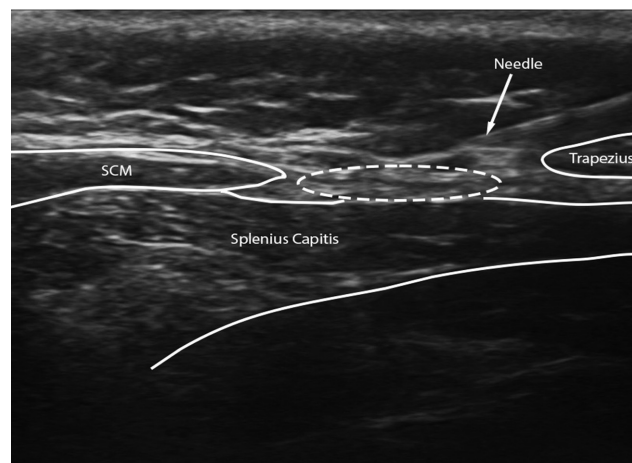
Transverse view of the lesser occipital nerve (LON) on ultrasound mid-injection. The LON is within the white dashed oval. The pre-injection image can be found in –Supplementary Fig. S2. Anatomical landmarks such as the sternocleidomastoid (SCM), splenius capitis, and trapezius are included.
